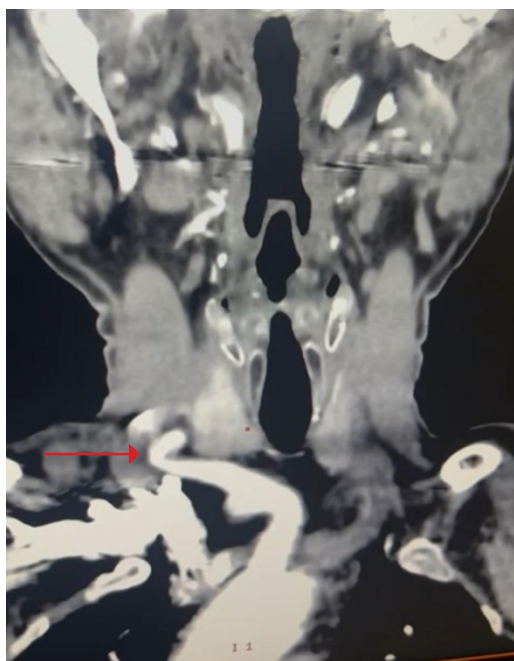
Coronal view of the computed tomography angiography. Red arrow shows the kinked right common carotid artery.
